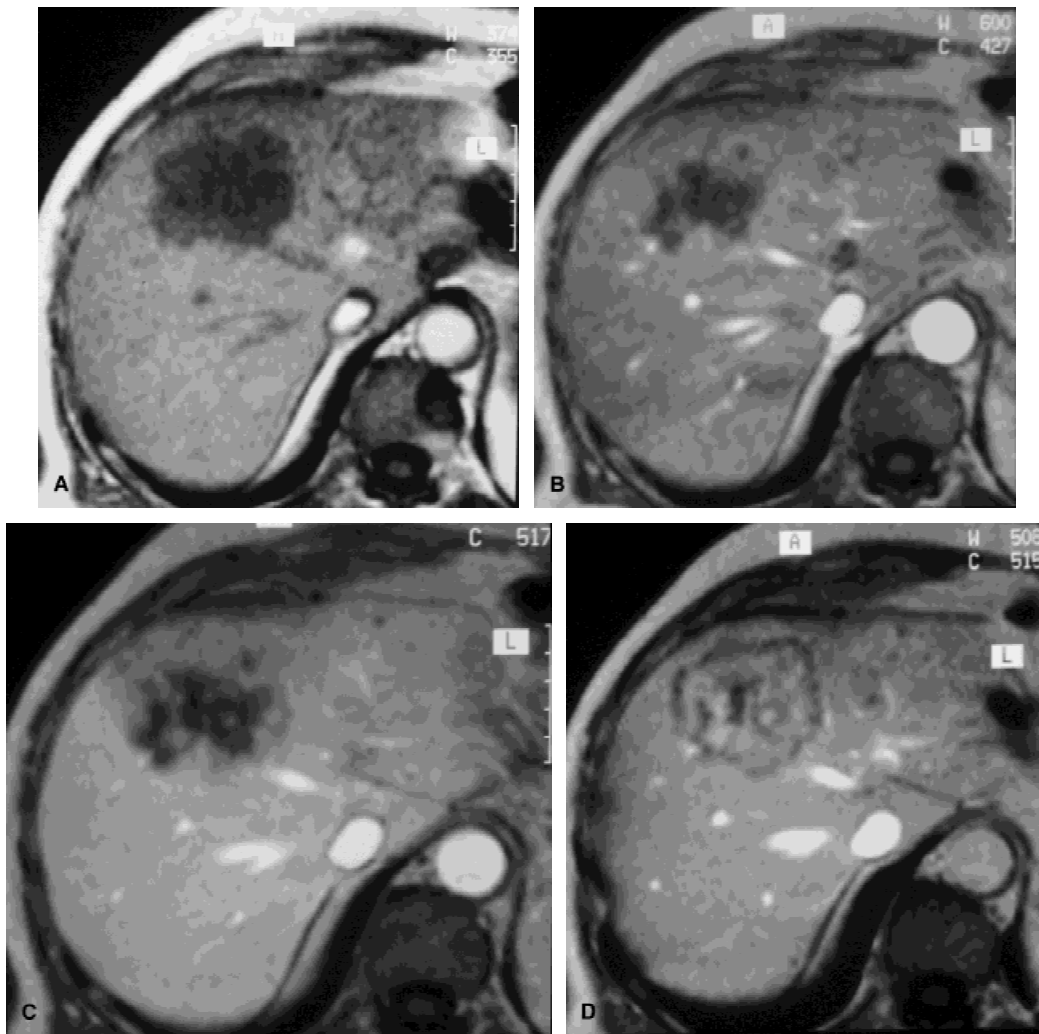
Metastasis in a patient previously operated on for colon carcinoma with dynamic administration of Gd-BOPTA showing peripheral washout. a: GRE transverse T1 precontrast image. Large lesion with cauliflower aspect is homogeneously hypointense. b: During the arterial phase with bolus administration of Gd-BOPTA (GRE transverse T1-weighted), the large lesion at shows a fleeting ring enhancement that blurs the margins of the lesions. c: In the portal venous phase the enhancement progresses centrally. d: At the equilibrium phase a peripheral hypointense rim ("peripheral washout" sign) can be seen.
